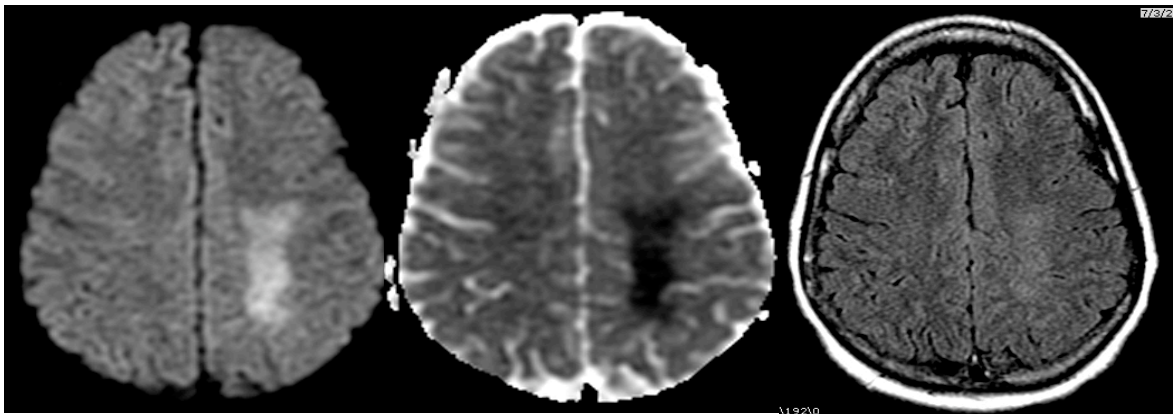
54 year-old patient presented 18 days following a severe hypoxic event with active use of benzodiazepines, opiates, and cocaine. Images (left to right: DWI, ADC, FLAIR) show increased DWI signal with corresponding low ADC in bilateral subcortical white matter. Patient made remarkable clinical recovery and imaging resolution
